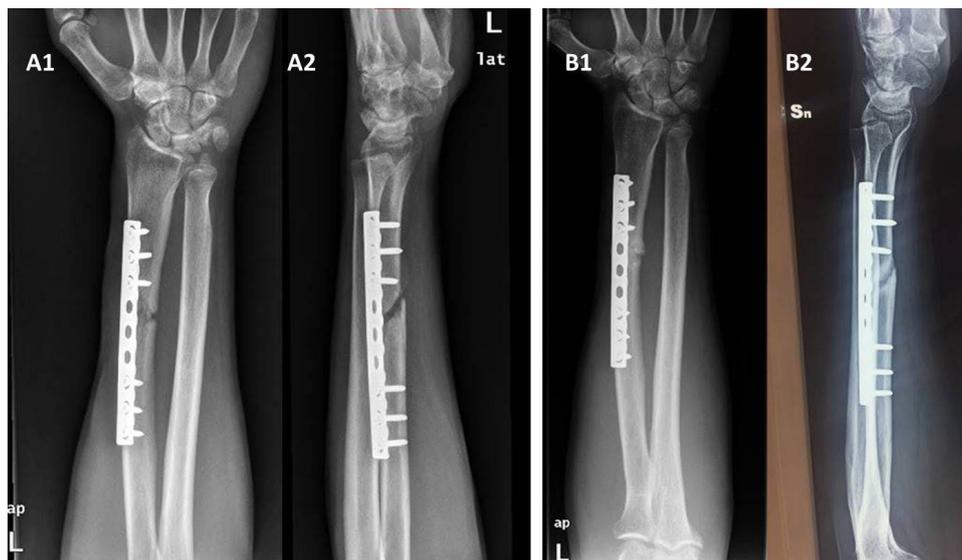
The X-ray images of a 54-year-old male showing the non-union of the left radial fracture. Before ESWT (T0) there were two open cortices in the two projections (A1 and A2). After 6 months (T3) three cortices were closed (B1 and B2).
